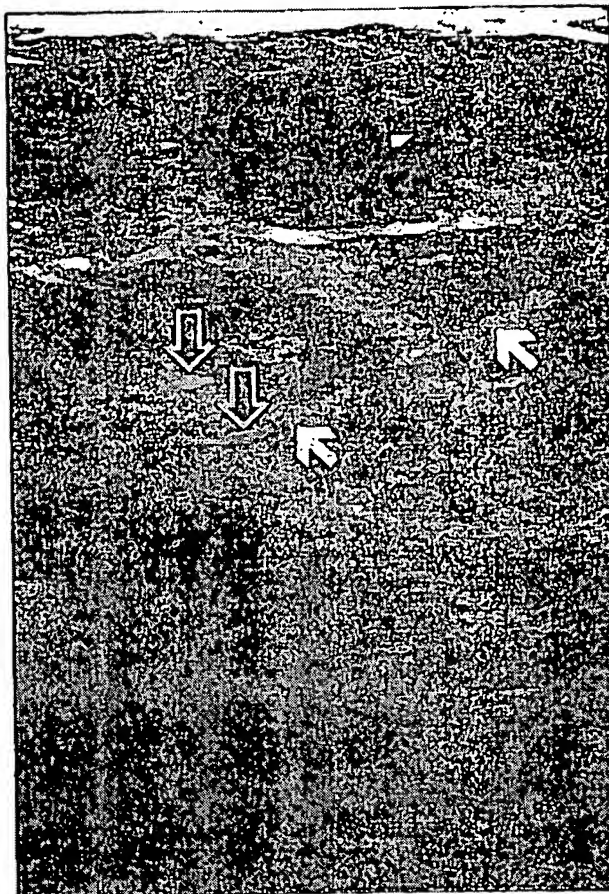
With sonogram guidance, antiretinal real-time compound breast sonogram image of left breast at 12 o'clock position shows needle localization wire (solid white arrows) placed into region of Gel Mark Ultra pellets (Seno Rx) (hollow white arrows) within recent stereotactic biopsy cavity.
